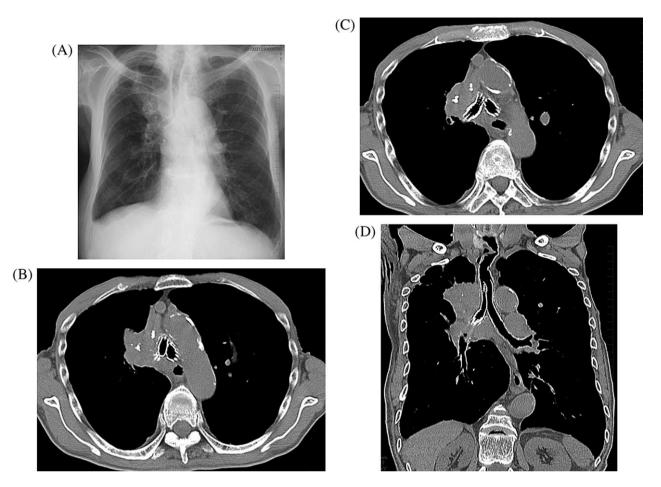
The images obtained 1 week after the bilateral stenting are shown: chest X-ray (A), computed tomography (B, C), and multiplanar reconstruction coronal image (D). Bilateral stents were patent and adjacent to each other (B, C), each of the proximal ends was in line with each other without migration (D).
